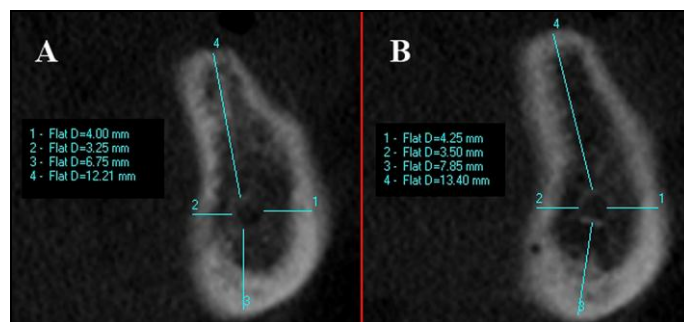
Measurements performed in the molar (A) and premolar (B) regions of an edentulous mandible. CBCT, coronal MPR.
